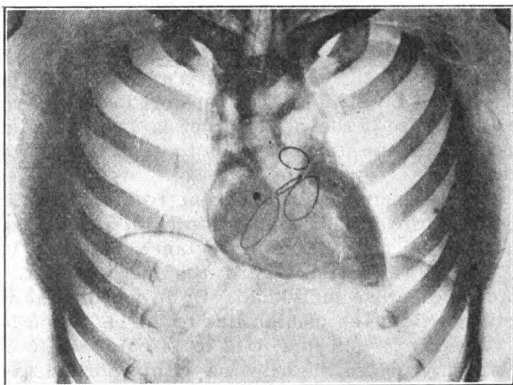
Radiograph made at distance of 72 inches. Correct size of heart in relationship to the interior chest wall.
